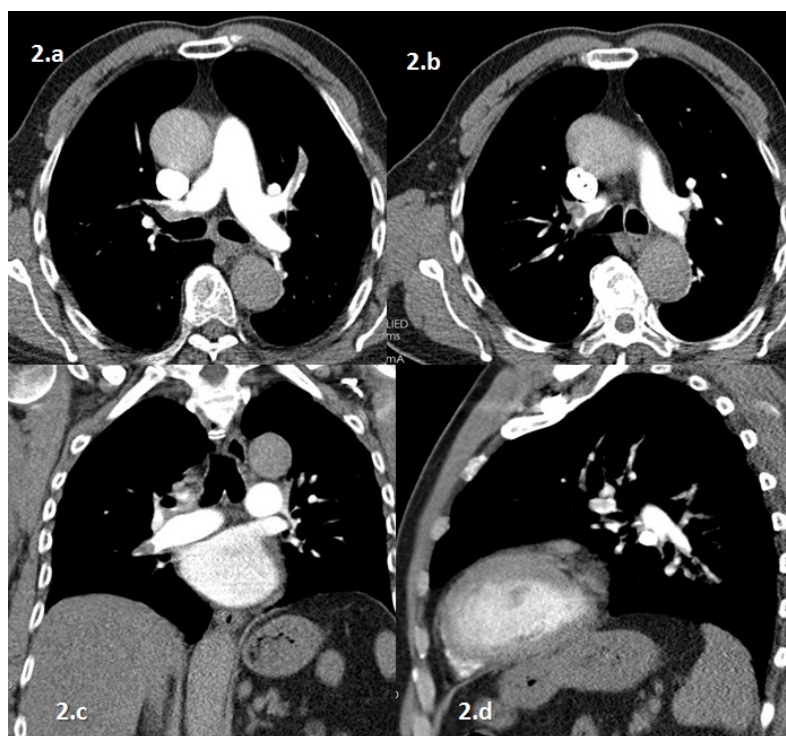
In Pt.#171, 68 years old, male patient treated with total knee arthroplasty, pulmonary embolism in left upper pulmonary segment artery and subtotal embolism both sides were stated in the pulmonary CT-angiography. Axial (a-b), coronal (c) and sagittal (d) CT views were seen in the figure.
